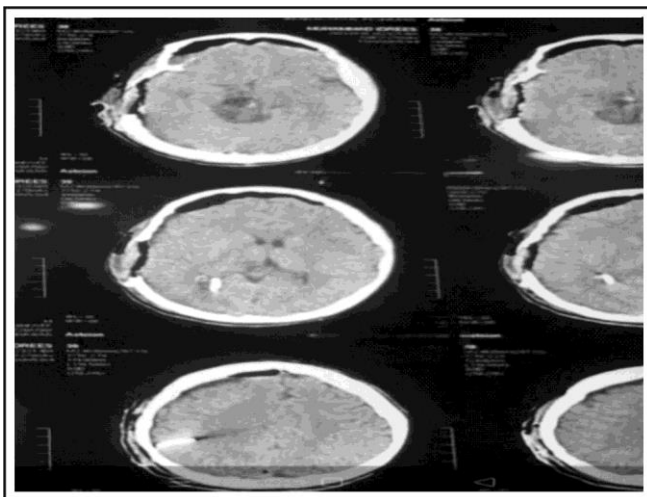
Post-operative MRI indicating resection rate of mid-brain tumor (Image added with patient consent).
